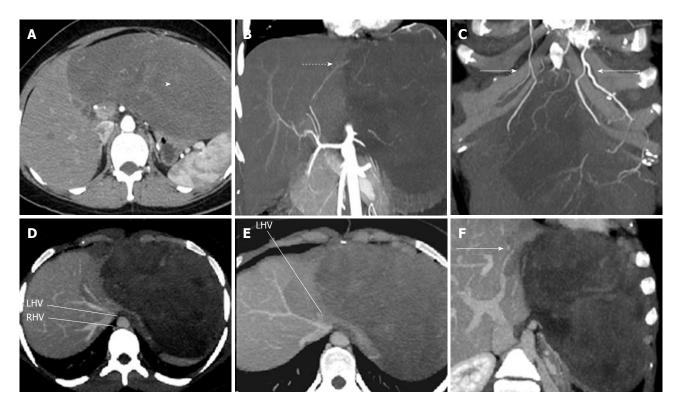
A 28-year-old lady with low grade fibromyxoid sarcoma on dynamic computed tomography. A: Soft tissue homogenously enhancing mildly hypodense mass (arrowhead) in the region of left lobe of liver is seen on the arterial phase of the dynamic triple phase computed tomography scan; B: The mass shows small arterial feeders from the left hepatic artery (dotted arrow); C: Large feeders from bilateral internal mammary arteries (solid arrows) to the mass are seen; D: Middle hepatic vein and right hepatic vein show normal patency and course; E: Left hepatic vein is only seen at the ostium, appears compressed by the mass and is not seen beyond the ostium; F: Left portal vein (solid arrow) is also splayed and partially attenuated by the tumor.
